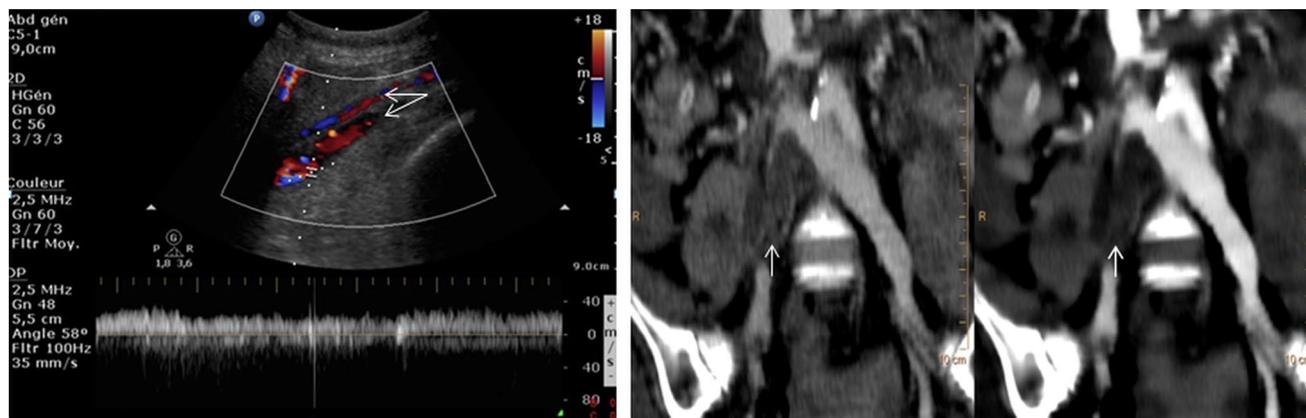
Left: cranio-caudal flux (orange color) in the CRRT catheter and in the right iliac vein (double arrow) on abdominal Doppler ultrasound examination. Right: frontal imaging of the deep venous (iliac) thrombosis (arrow) on abdomen computed tomography
